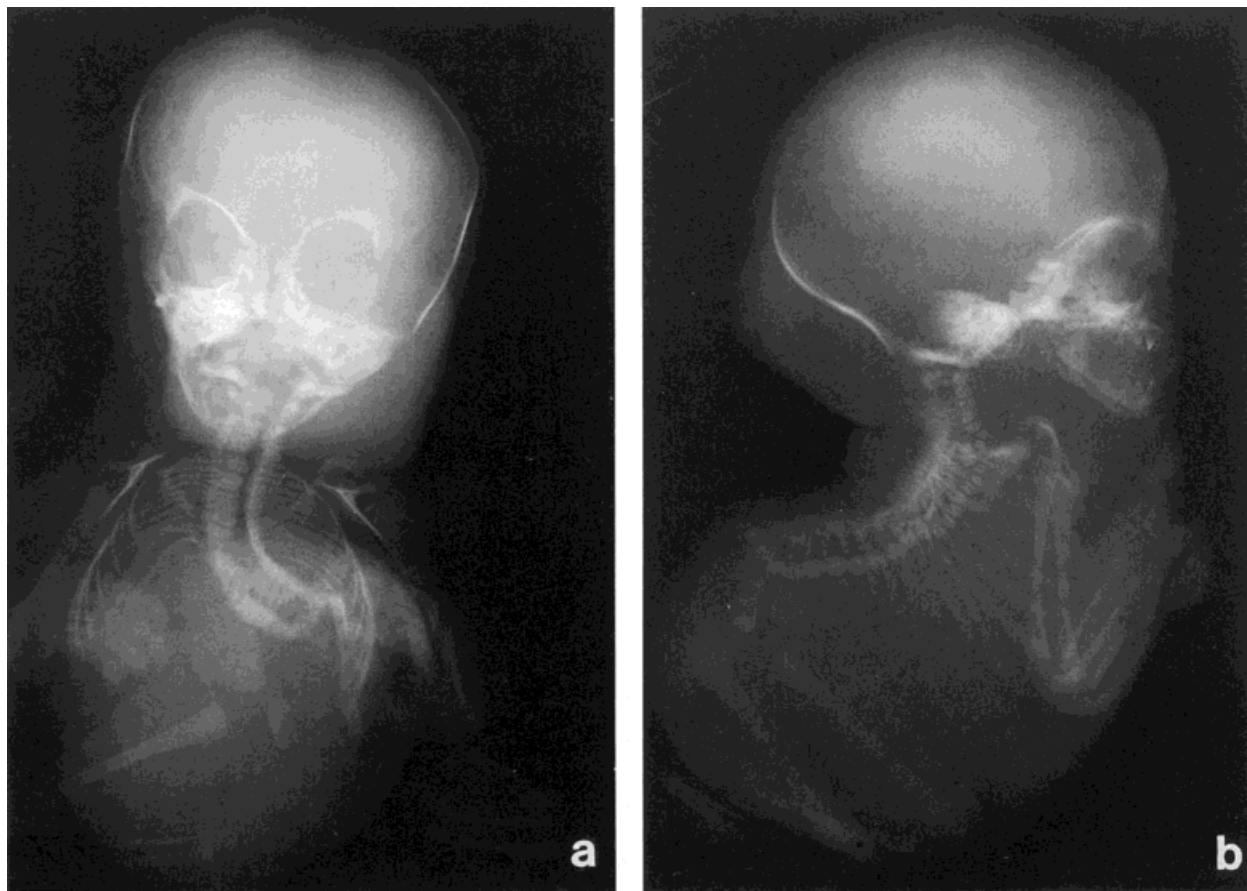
Anteroposterior (a) and lateral (b) views of full body radiograph of patient 1.
